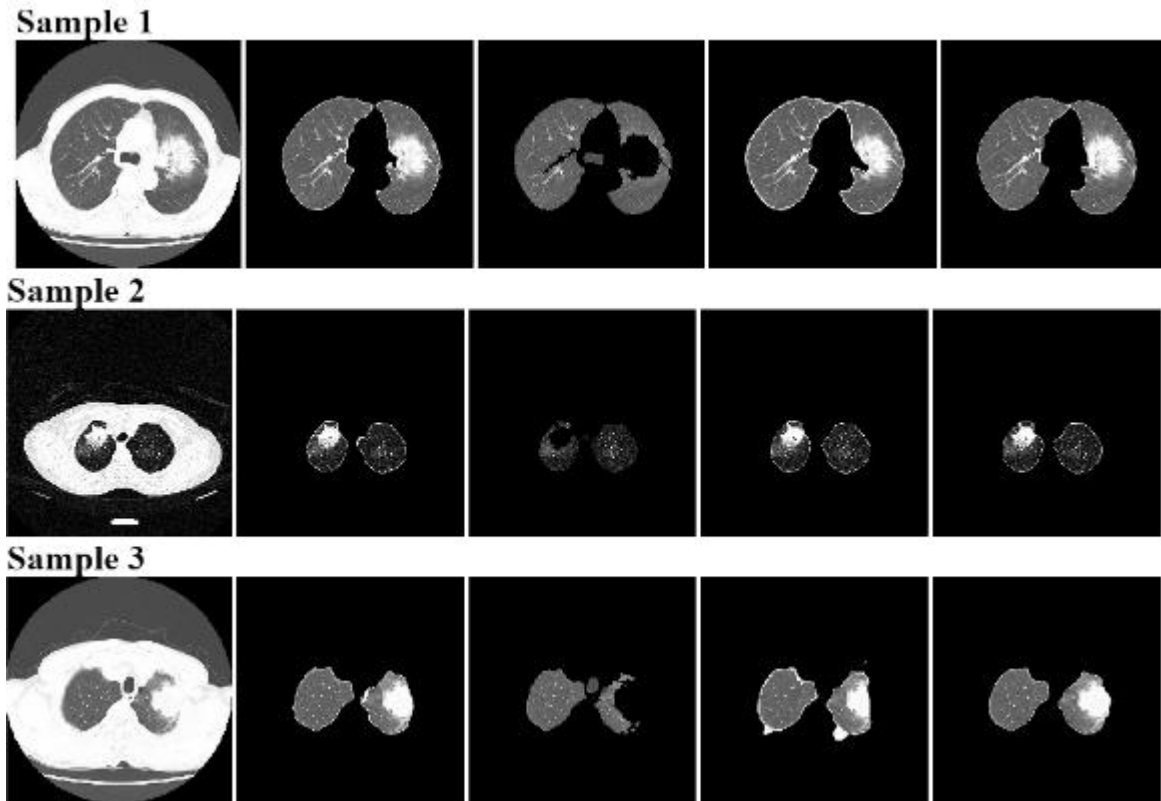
Qualitative segmentation performance assessment of T2 class CT imageries
